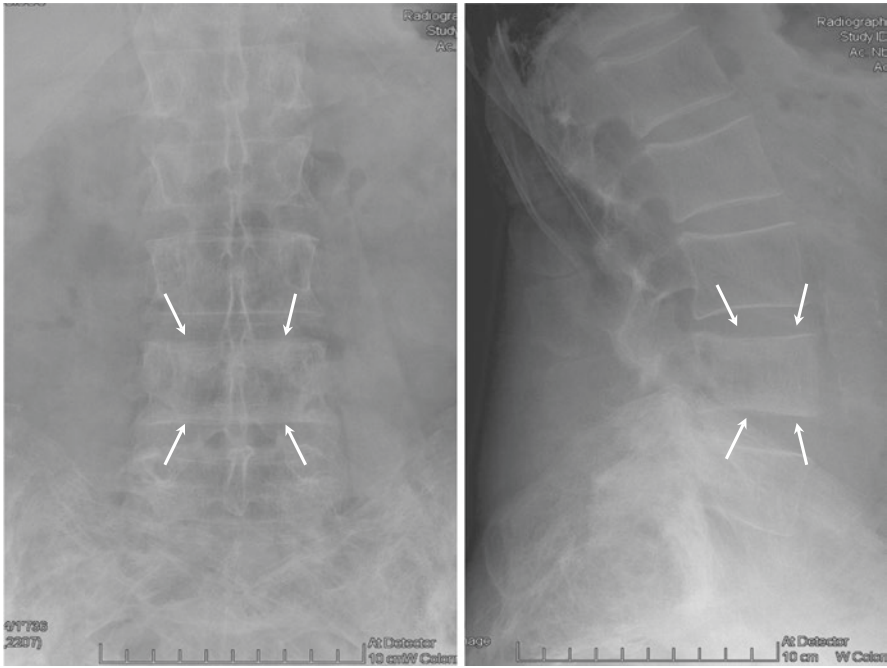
Radiographs showing periosteal and endosteal bone apposition parallel to the end plates of L4
